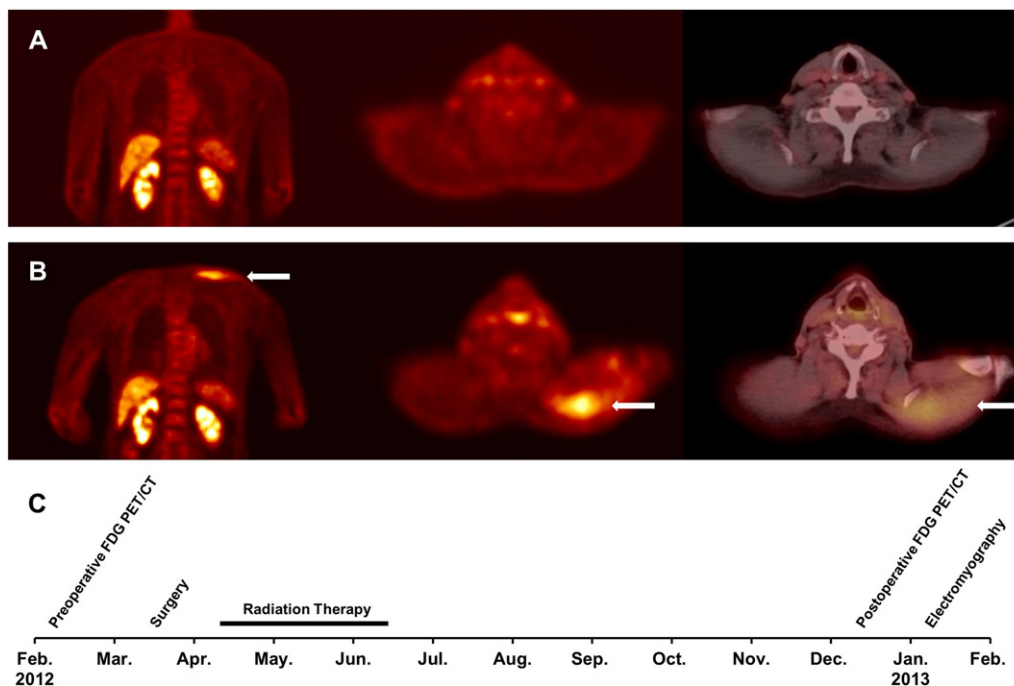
A 78-year-old man with left submandibular gland cancer. The patient underwent left submandibular gland resection with neck dissection and adjuvant radiation therapy. Postoperative ^{18}F -FDG-PET/CT scans showed definitely increased ^{18}F -FDG uptake in the left trapezius muscle (arrows). (A) Preoperative and (B) postoperative PET/CT images. (C) Clinical course of the patient.
